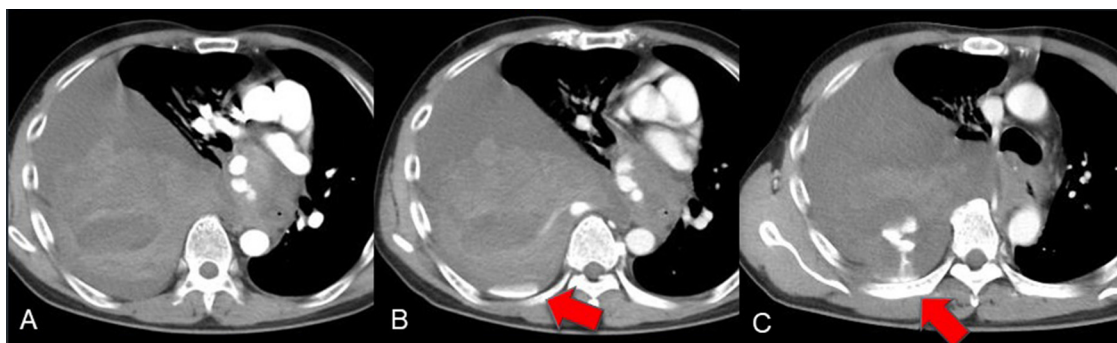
(A) A Contrast-enhanced computed tomography (CT) scan reveals hemothorax in arterial phase. (B, C) A Contrast-enhanced CT scan in venous phase reveals extravasation (arrow) in the middle mediastinum from the bronchial artery.
